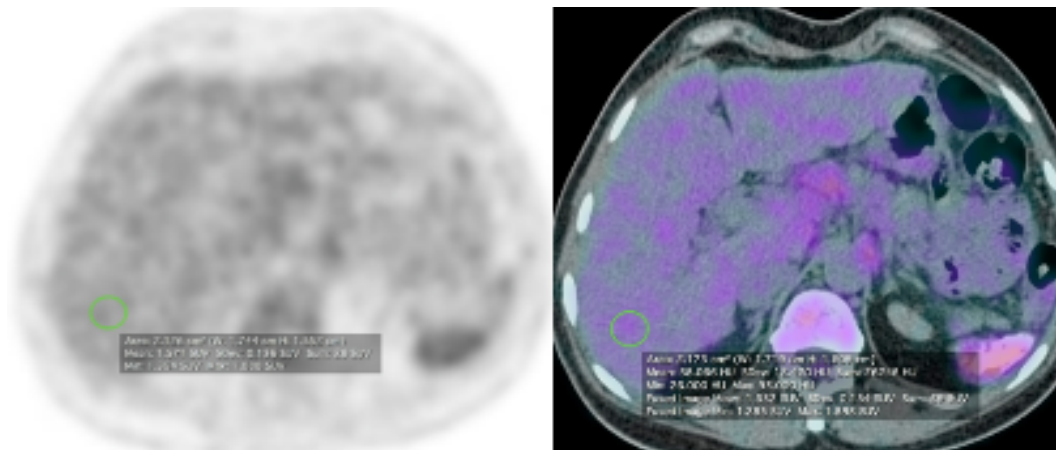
small ROI within the right hepatic lobe, with SUVmean~1.5 and SUVmax~2.0 ~2.0 axial fused PET/CT image (right) and PET image (left).
